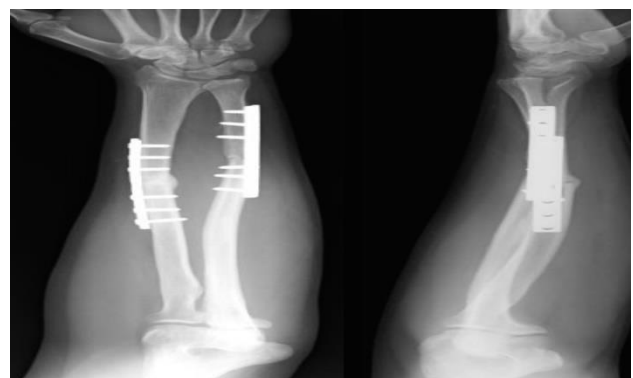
3 Months post-operative x-ray.
